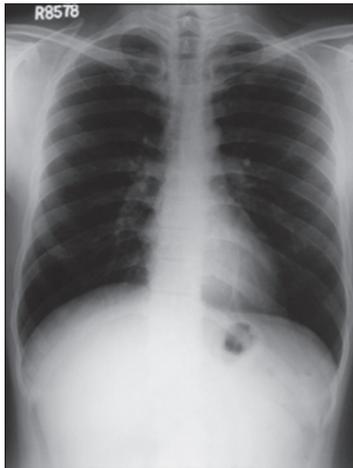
Chest radiograph showing no foci of infection
